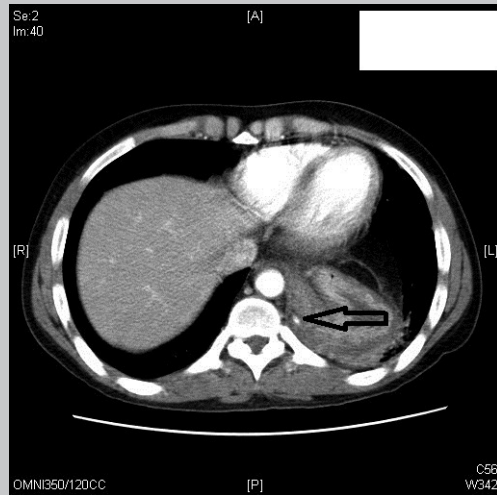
Computed tomography scan of chest and abdomen showing that the artery now can be traced into the thorax.
